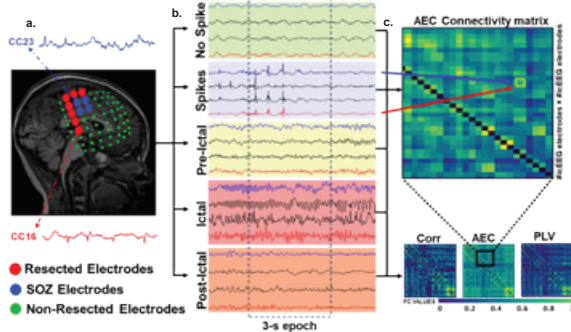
Functional connectivity measures for icEEG recordings. (a) The MRI shows resected (red), non-resected (green), and SOZ (blue) electrodes. (b) Interictal and ictal data containing different neuronal conditions. (c) AEC, PLV and Corr matrices generated from each 3-second epoch computed for all data. AEC matrix shows the FC value of the neural activity recorded from CC16 and CC23 electrodes.
